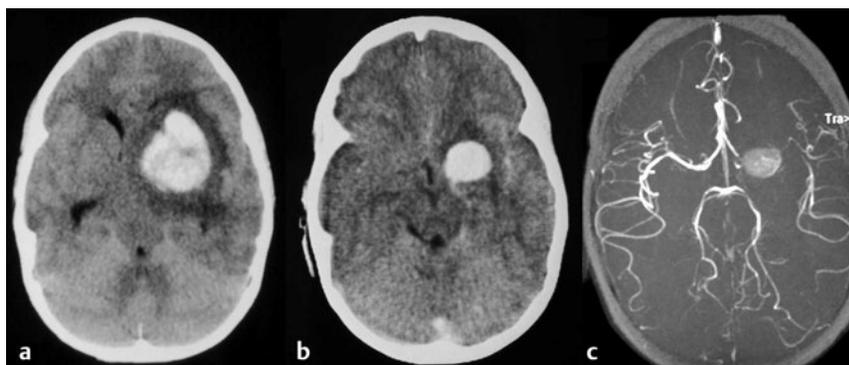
Saccular aneurysm in an 8-year-old boy. (a) Computed tomographic CT scan of the head showing a spontaneous deep hematoma. (b) Contrast-enhanced CT scan of the head showing a giant aneurysm after resolution of the hematoma. (c) Magnetic resonance angiogram showing the same aneurysm.
